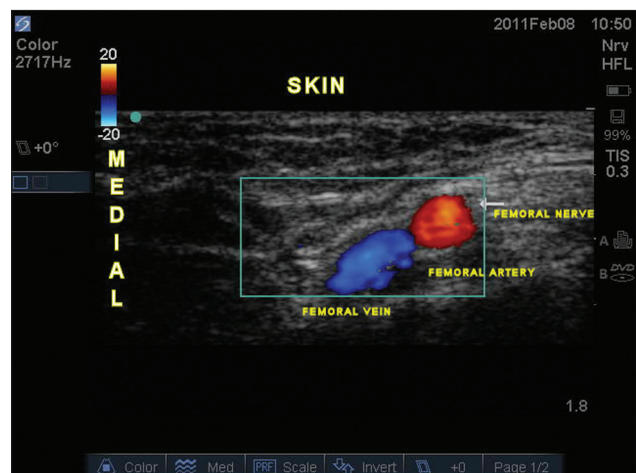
Color Doppler view of the femoral area
